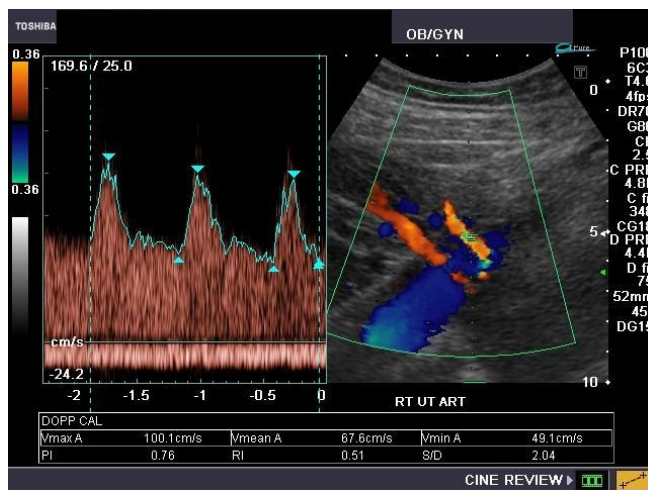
Ultrasound image with conventional color Doppler showing the uterine artery and the external iliac artery. Normal flow velocity waveforms from the uterine artery at 24 weeks of gestation demonstrating high diastolic flow.
